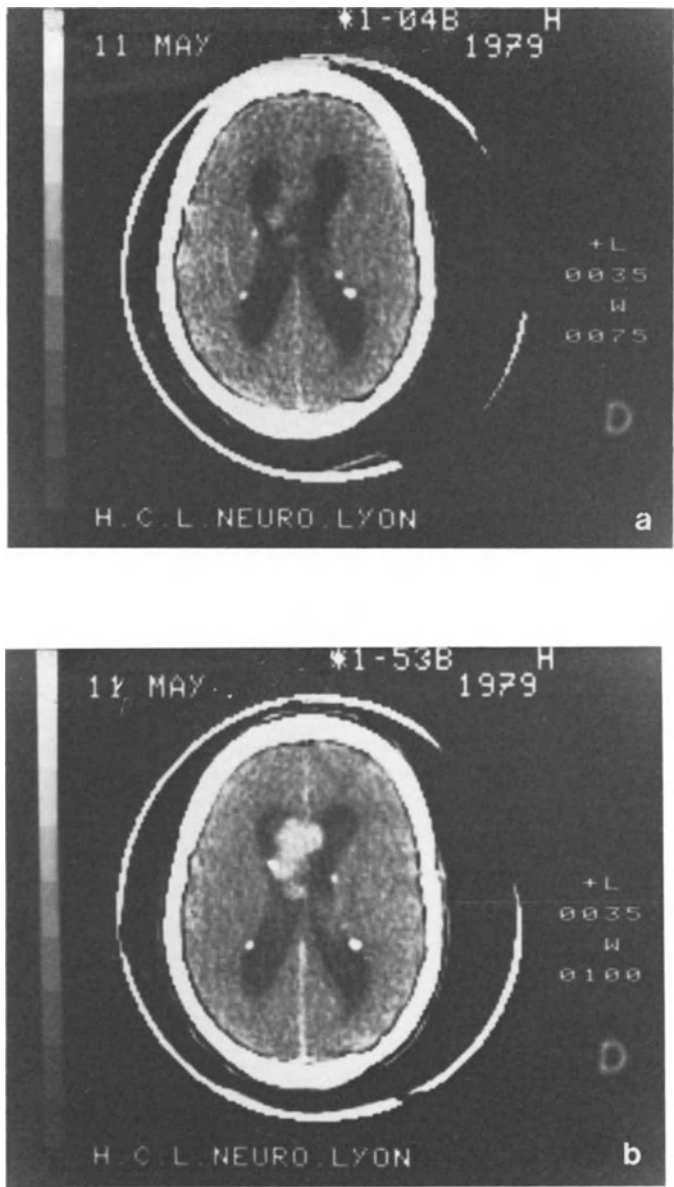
Grade I ependymoma in a patient with tuberous sclerosis. Note the calcifications remote from the neoplasm. a) Pre-contrast CT. b) Post-contrast CT
